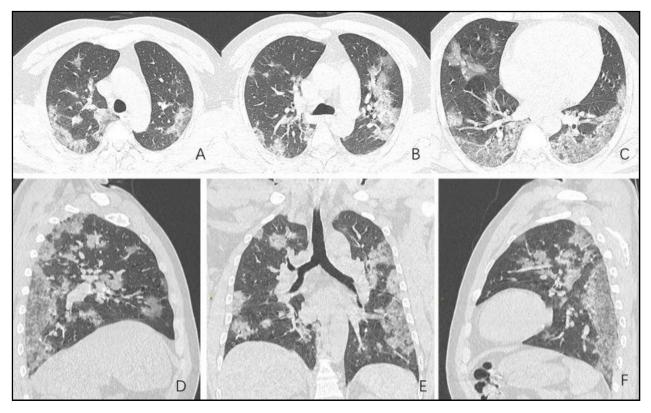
CT Images of a 44-year-old man with COVID-19 pneumonia.
